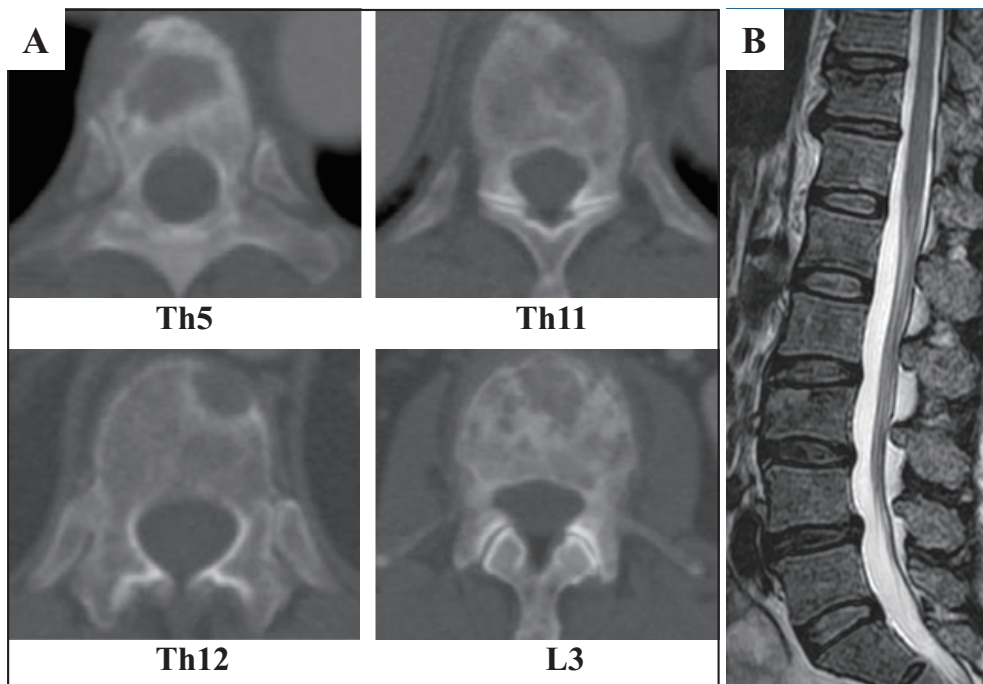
Pretreatment CT and MRI scan images.
